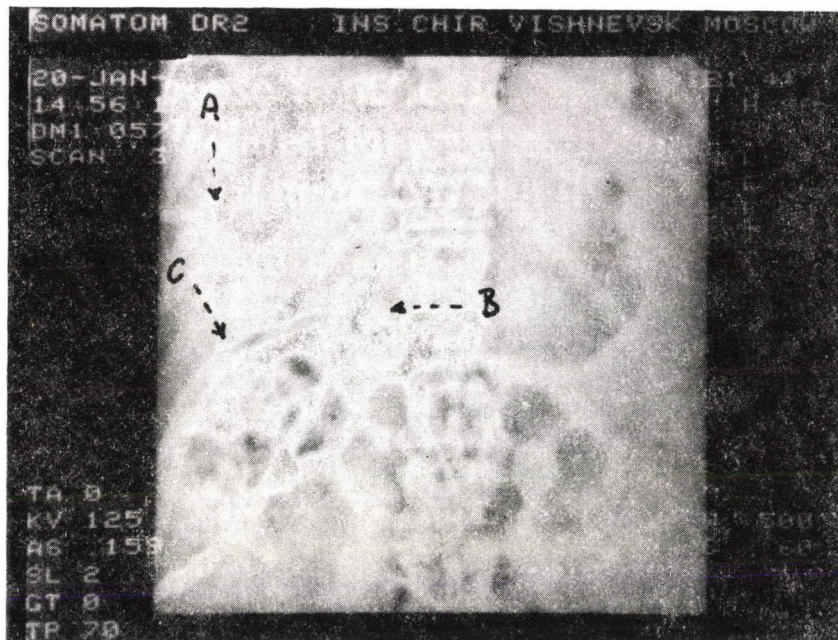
The CT scan shows two percutaneous drains (A and B) as well as the shadow of the Winslow drain
